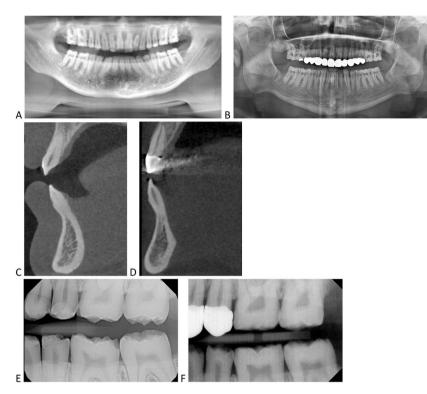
A, Panoramic radiograph, sibling A. B, Panoramic radiograph, sibling B. C. CBCT cross section of incisors, sibling A. D, CBCT cross section of incisors, sibling B. E, Bitewing radiograph, sibling A. F, Bitewing radiograph, sibling B.
